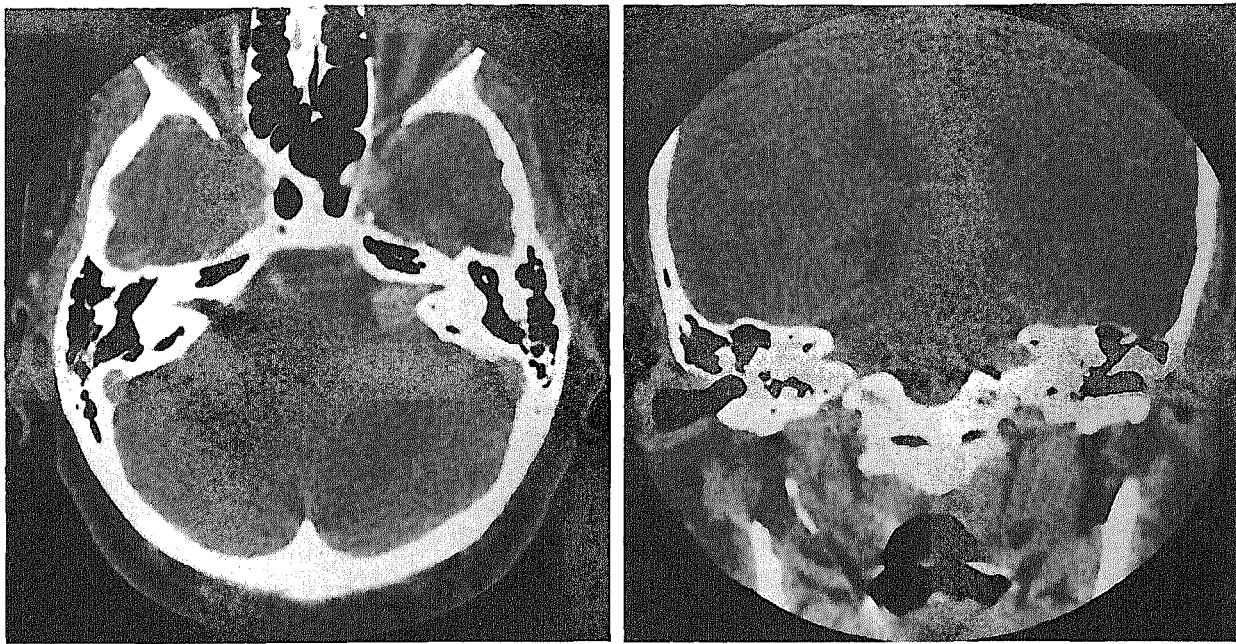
Left acoustic neuroma. Left, axial CT section; right, coronal CT section. The enhanced tumor mass fills the slightly dilated left internal auditory canal and protrudes into the adjacent cerebellopontine cistern.
